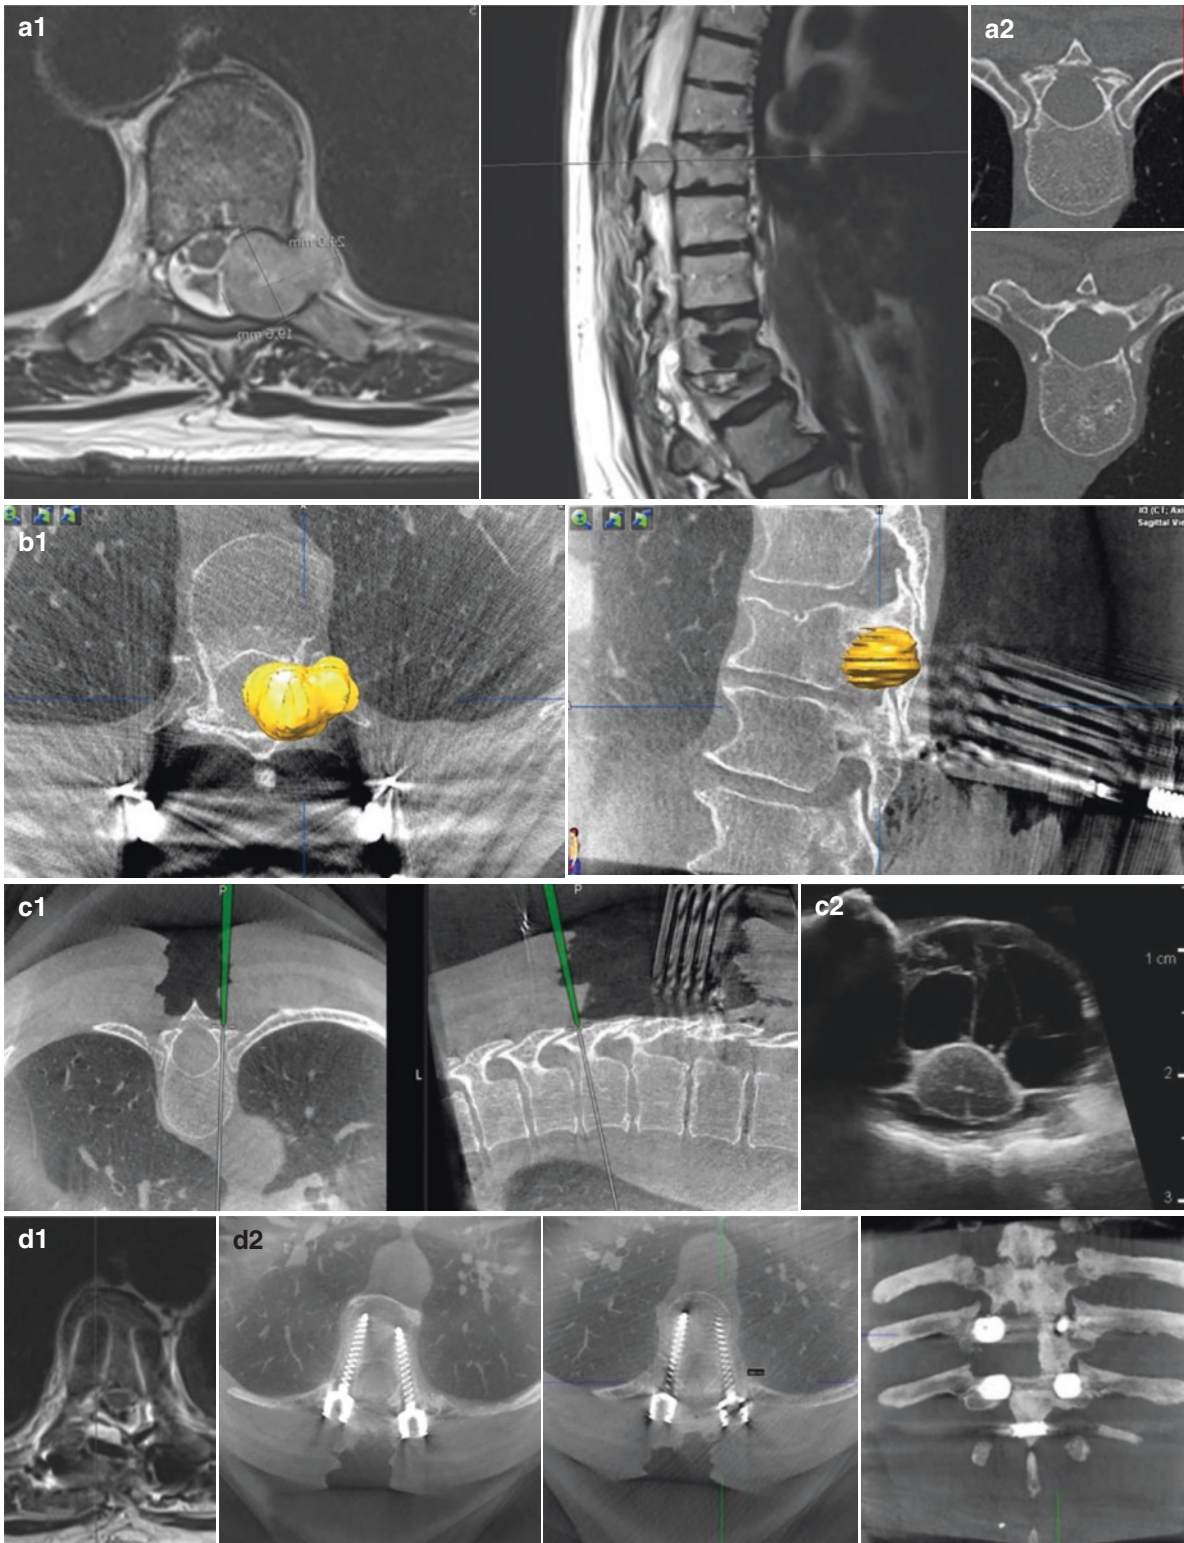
(a1) Preoperative T2 MRI—thoracic T8 dumbbell tumour with intra and extraspinal extension. There is also old osteoporotic fracture T12 and evidence of cement augmentation T11. (a2) CT—narrow ‘hairpin’ size pedicles at T7 and T8. (b1) Intraoperative 3D X-ray fused with preoperative imaging demonstrating tumour contour. (c1) Navigation guided pedicle cannulation using intraop 3D
